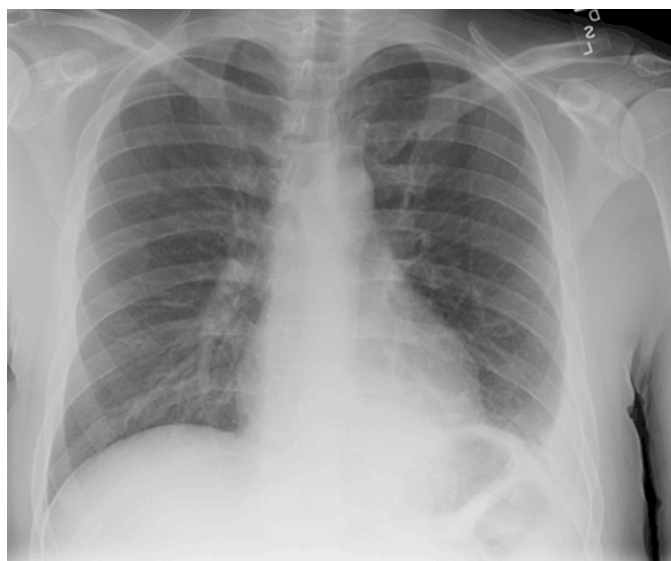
Chest X-ray one week prior to admission: Left lower lobe infiltrate and possible small left effusion suggesting pneumonia.
